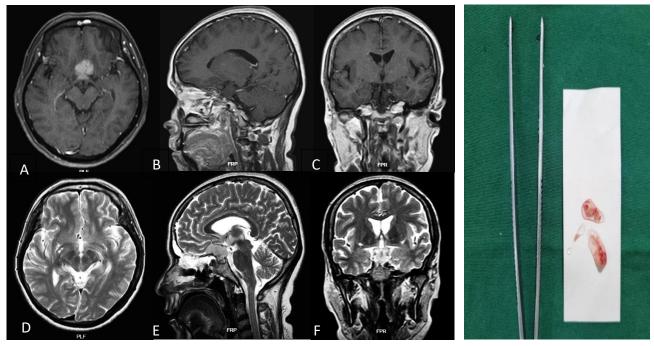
MRI brain of Case no. 2. (A) T1 axial with contrast, (B) T1 sagittal with contrast, (C) T1 Coronal with contrast, (D) T2 axial, (E) T2 Sagittal, (F) T2 Coronal, (G) Mass of Tumor Removal from case no. 2
